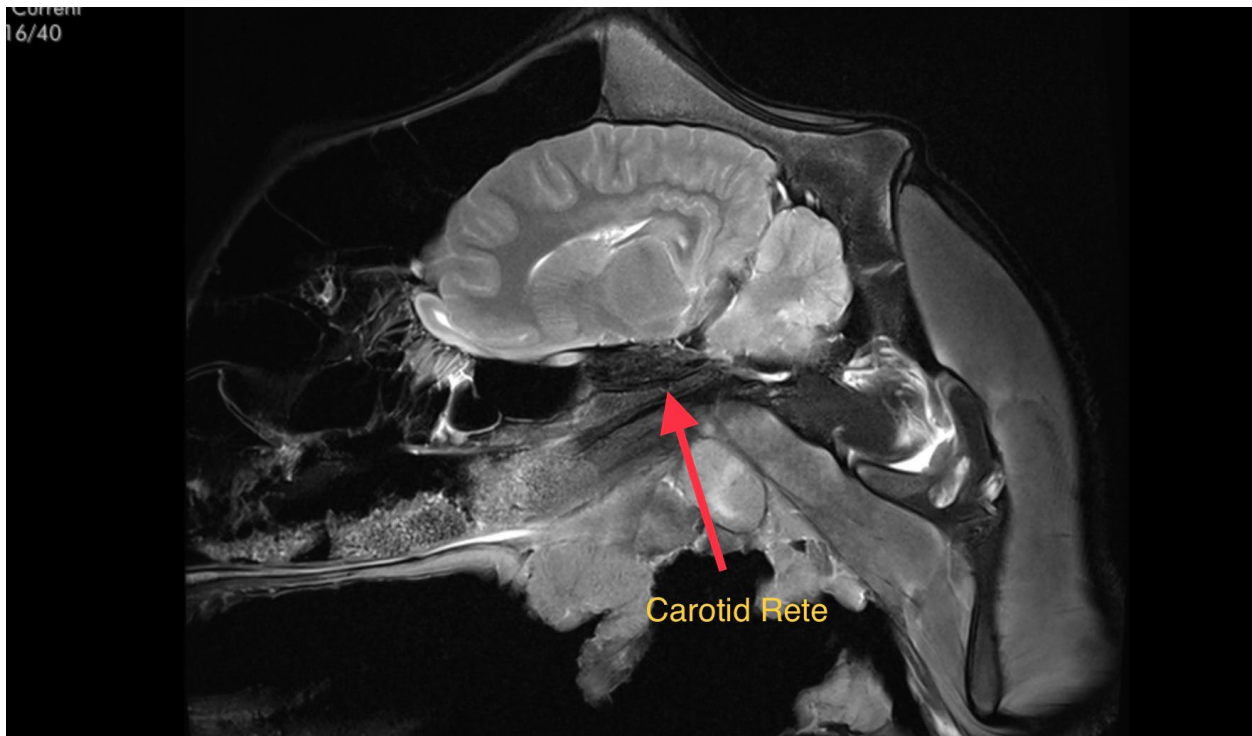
Sagittal view of the giraffe brain MRI showing the carotid rete
